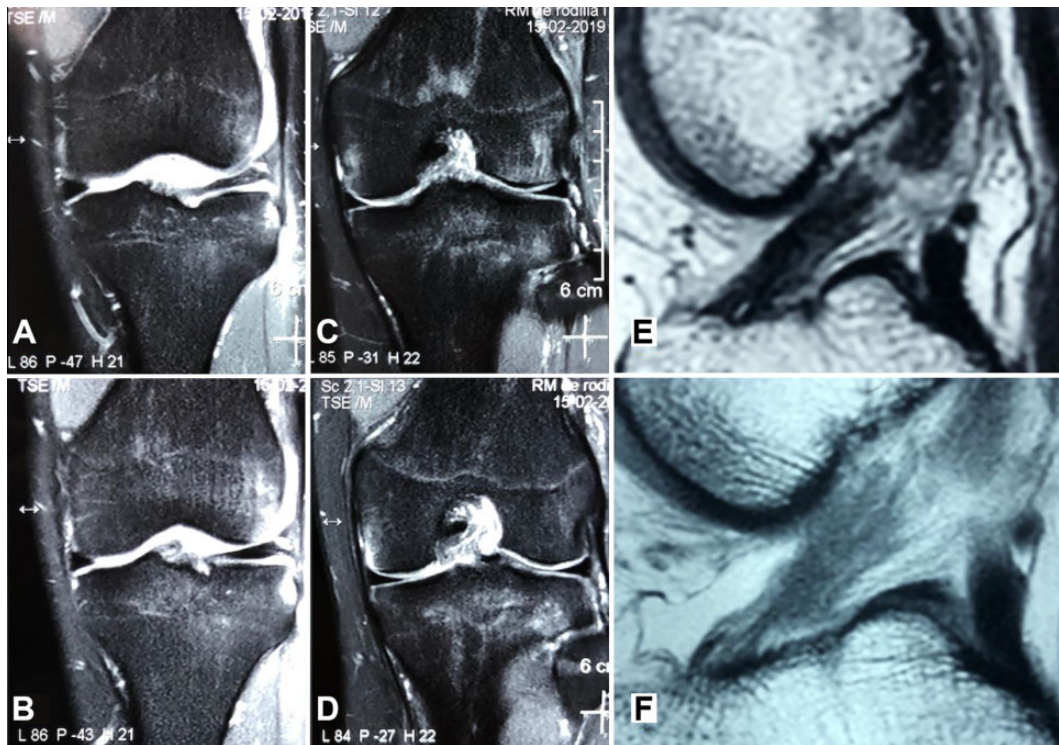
Magnetic resonance imaging scans of an acute, proximal anterior cruciate ligament (ACL) tear. (A-D) Coronal T2 weighted images with sequences progressing posteriorly to anteriorly demonstrating edema in the proximal aspect of the ACL. (E-F) T1-weighted sagittal images demonstrating attenuation in the proximal one-third of the ACL.
